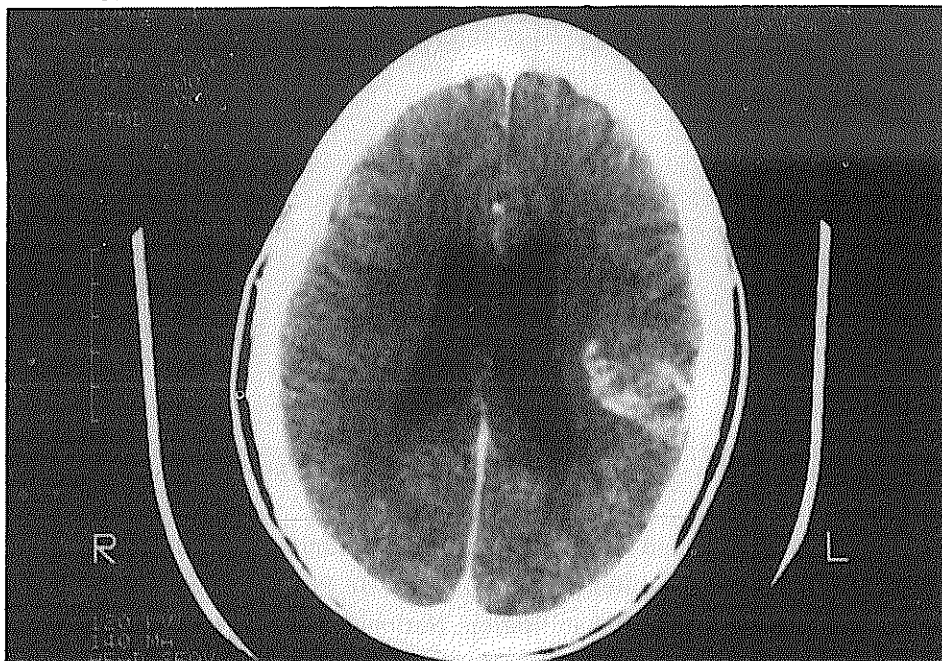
Contrast CT of patient 1 obtained eight days after onset: A single area of decreased density in the left temporoparietal lobe with heterogenous enhancement.
